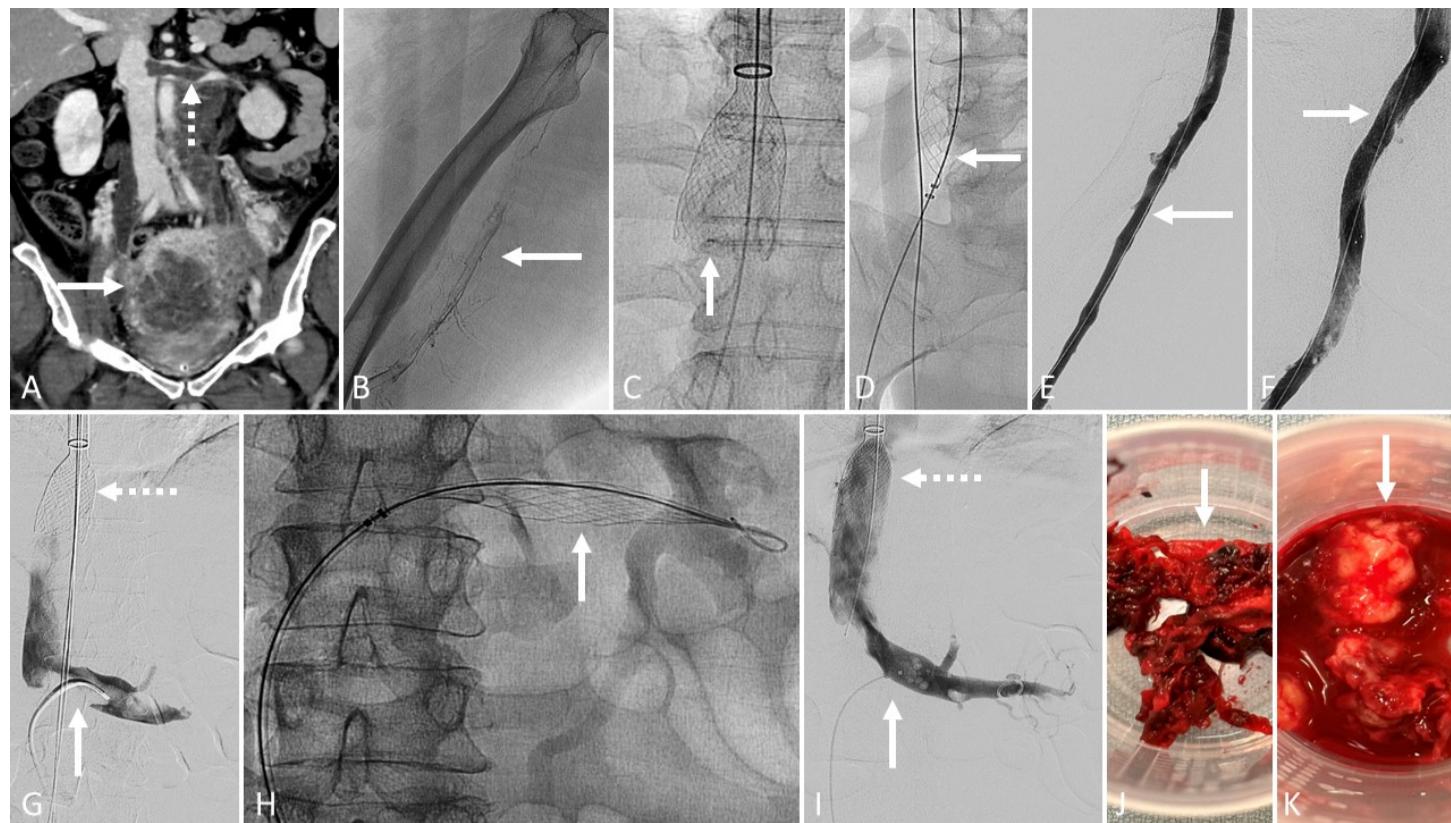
CT venography demonstrated a large necrotic cervical mass (A; solid arrow) with metastatic lymphadenopathy and chronic thrombus in the right iliocaval and iliofemoral segments and left renal vein (A; dashed arrow). Preprocedural venography of the right lower extremity confirmed acute occlusive thrombus (B). The Protrieve funnel was deployed in the patent suprahepatic IVC (C). The ClotTriever thrombectomy catheter was deployed (D). Completion venography confirmed clearance of thrombus from the right lower extremity, and brisk in-line flow (E). A stent was placed in the right common iliac and external iliac veins (F). Left renal venography showed non-occlusive thrombus (G; solid arrow). The Protrieve sheath remained in place (G; dashed arrow). The InThrill thrombectomy catheter (H; arrow) was used to remove thrombus from the left renal vein. Completion left renal venography confirmed removal of thrombus and brisk in-line flow (I; solid arrow). The Protrieve sheath (I; dashed arrow). Thrombus extracted from the lower right extremity (J) and Protrieve sheath (K).
